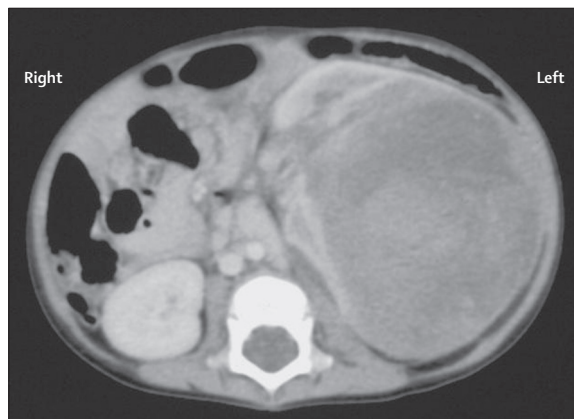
CT scan of the abdomen at diagnosis showing a left renal rhabdoid tumour
